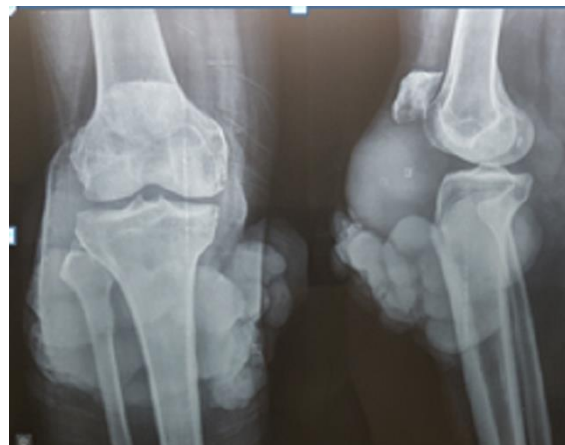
X-ray of right knee joint
